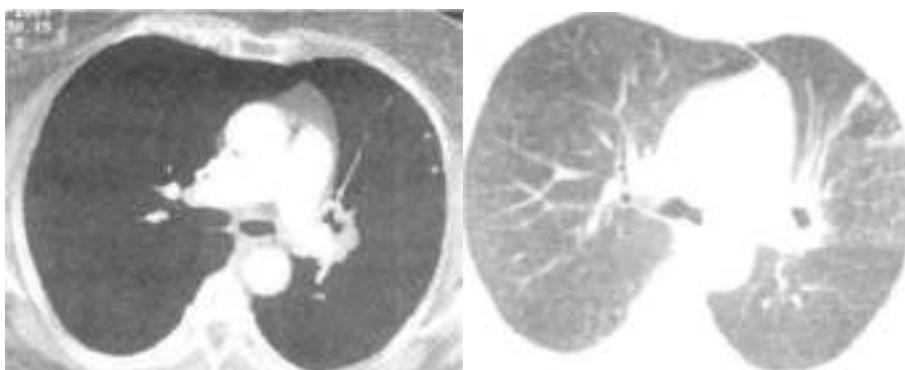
Tuberculosis of the bronchus of the upper lobe of the left lung. CT angiography. In the bronchopulmonary node at the root of the left lung, there is a cavity of decay connected to the upper lobe bronchus by a fistulous tract. Bronchogenic contamination in the lung tissue.
